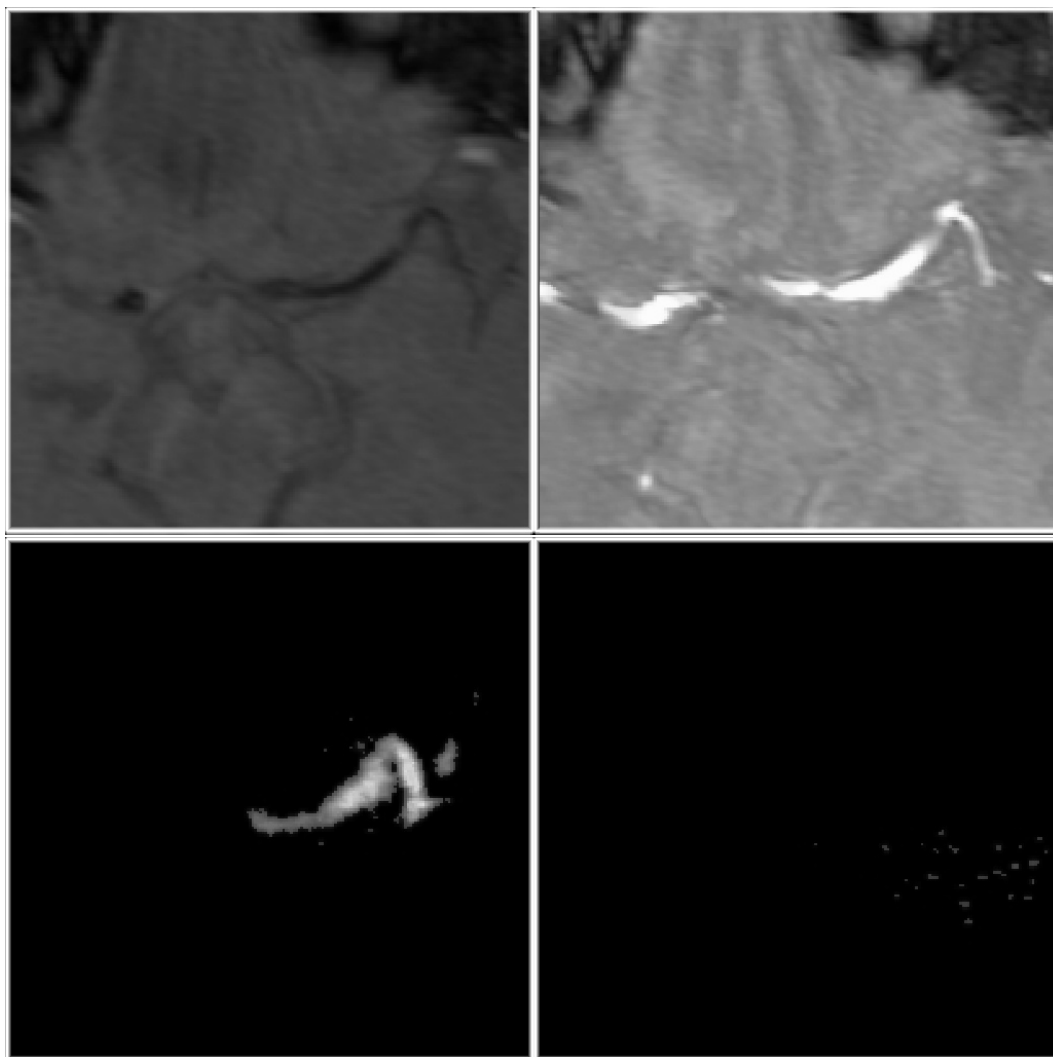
Dataset Aneurism1. Top left, MRI T1, and at top right, corresponding slice from MRA. Bottom left, USA #1, from before clamping. Bottom right, USA #2, from after clamping. Unregistered volumes.
